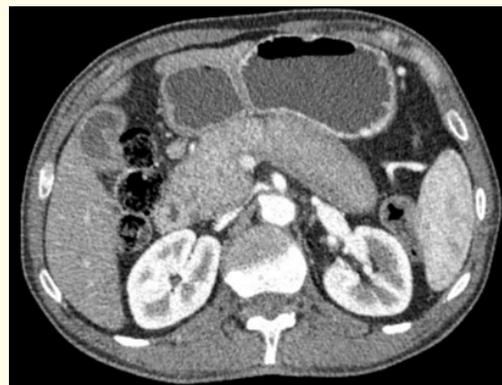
CT scan showing autoimmune pancreatitis.
